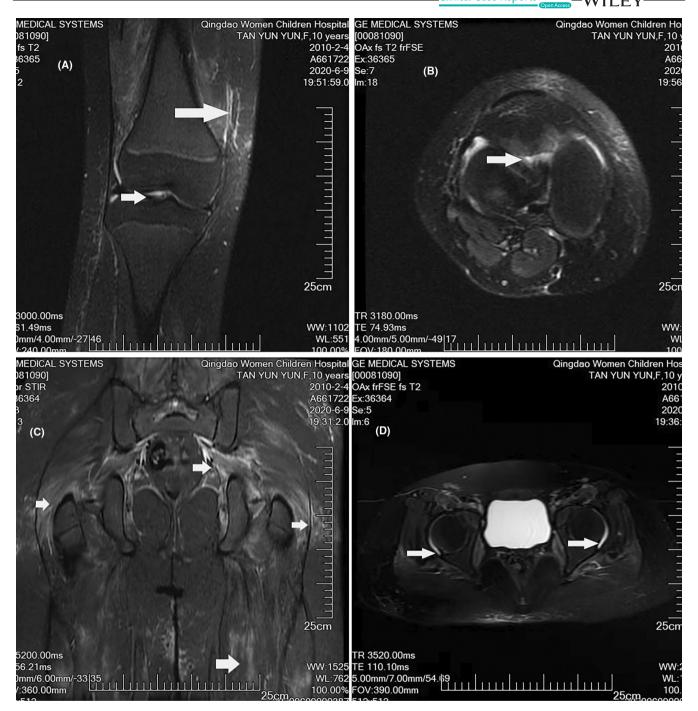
HRCT examination. (A, B) Soft tissue swelling with abnormal signal (arrows) around the right knee joint, and (C, D) diffuse abnormal signals (arrows) in bilateral hip.
